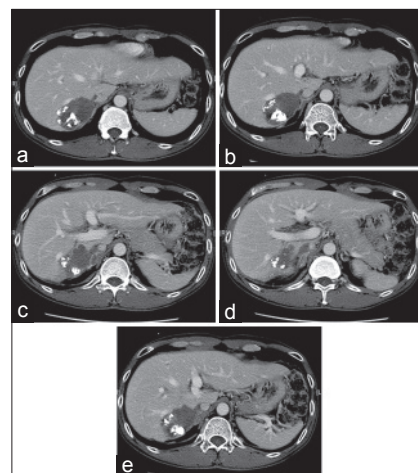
Preoperative computed tomographic scans showing tumor invasion of (a, b) the right hepatic vein, (c) the right adrenal gland, (d) the right adrenal vein, and (e) the inferior vena cava
